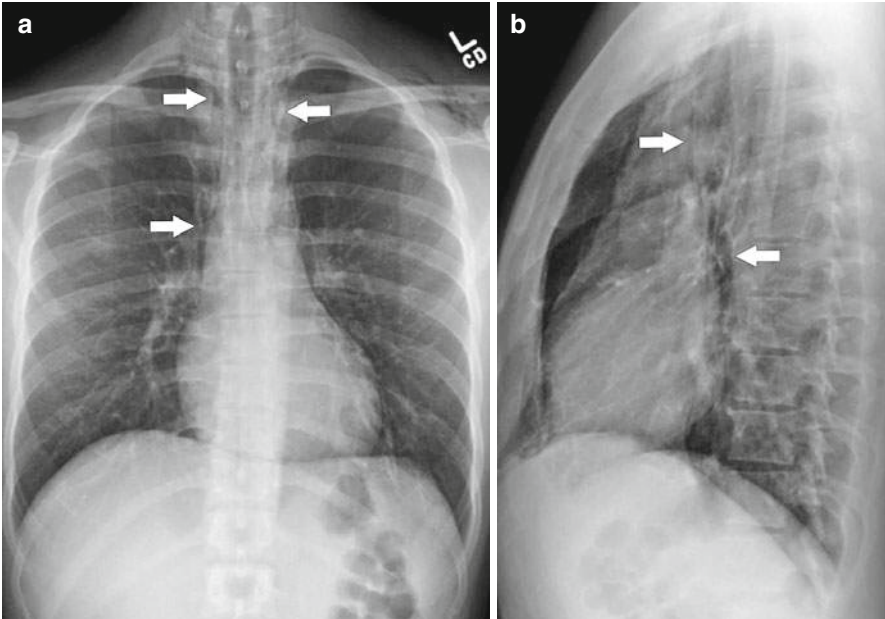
Pneumomediastinum. Chest X-ray posteroanterior (a) and lateral (b) views reveal mediastinal air (*arrows*) from an esophageal tear
